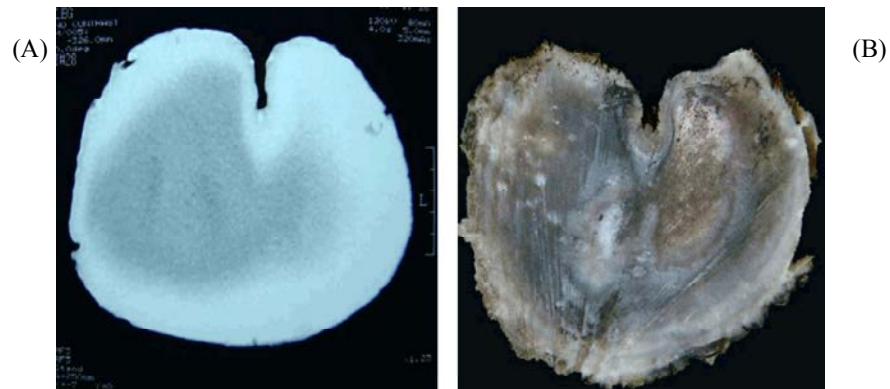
(A) Transverse CT image and (B) cross section at the level of the sole pad, showing some what round sole and interdigital notch.
